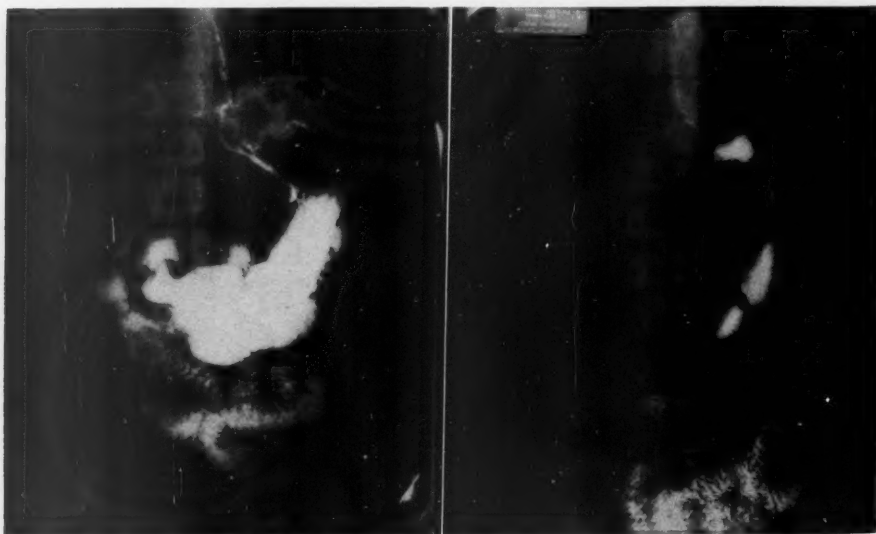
Leiomyosarcoma of the stomach. A preoperative roentgenogram; B, 5-month postoperative roentgenogram.
